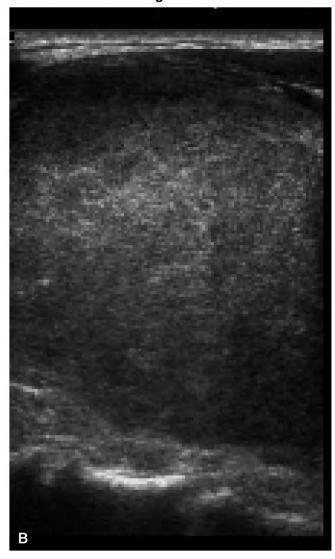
Ultrasound of anaplastic carcinoma in the left lobe. A, Transverse, anteroposterior diameter: 48 mm. B, Longitudinal.
